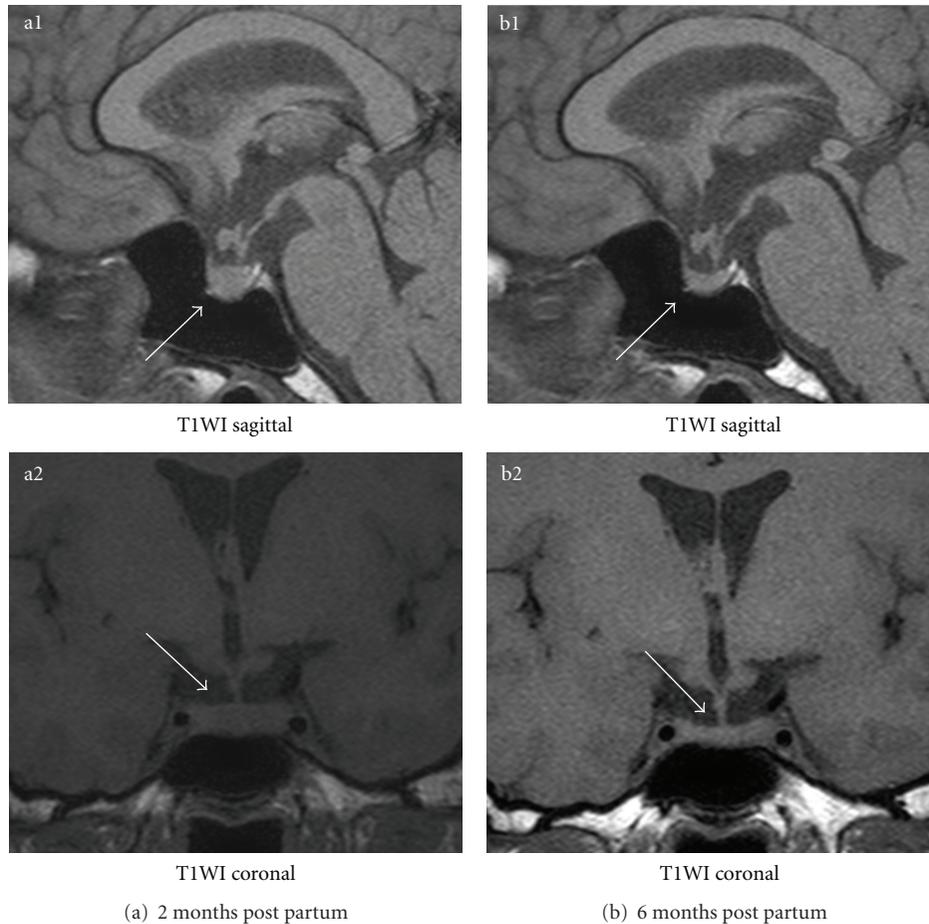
Sequential magnetic resonance imaging (MRI) (T1 weighted image: T1WI) demonstrated changes of the pituitary gland. At 2 months post partum, MRI revealed a normal pituitary gland ((a1) T1WI sagittal, (a2) T1WI coronal). At 6 months post partum, MRI revealed atrophy of the pituitary gland and empty sella ((b1) T1WI sagittal, (b2) T1WI coronal). At 6 months post partum, she had empty sella on MRI. The arrows indicate the pituitary gland.
